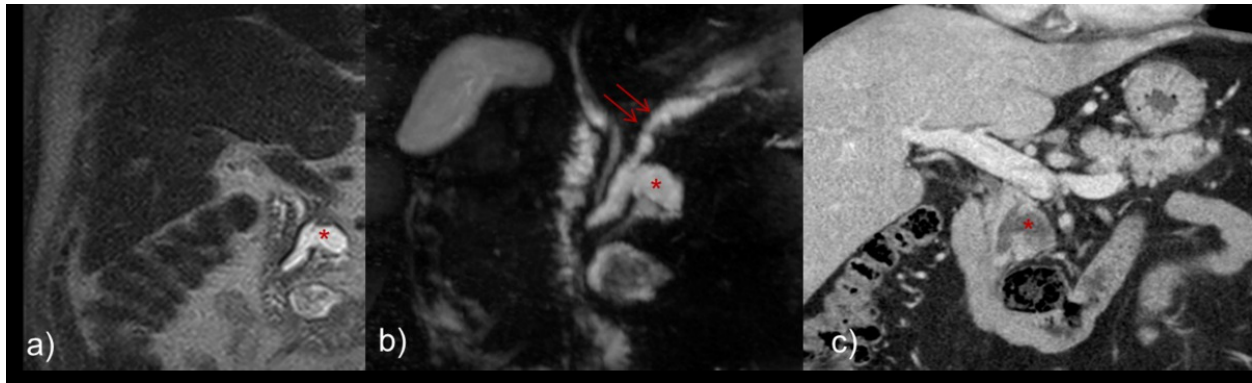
Coronal HASTE image a), coronal thick MRCP projection b) and enhanced coronal CT portal venous phase image c) of a patient with main pancreatic duct strictures and irregular dilatation with a pseudocyst in the pancreatic head communicating with the main pancreatic duct.
